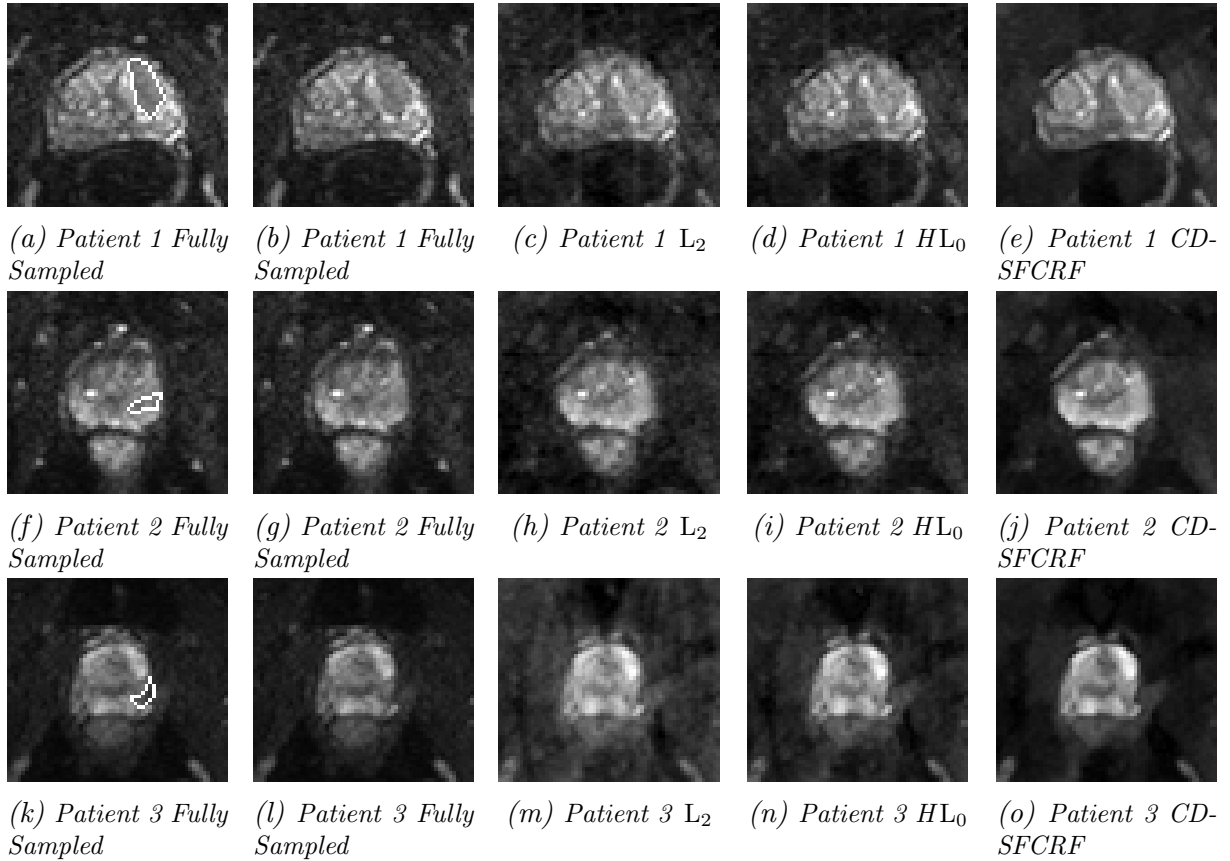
Sample DWI results ( $b = 100s/mm^2$ ) for three patient cases produced using CD-SFCRF,  $L_2$ , and  $HL_0$  at 32% spiral percentage sampled. Compared to other methods, CD-SFCRF preserves tissue details and contrast especially in the tumorous regions. The tumorous region in the fully sampled image is marked (a).
